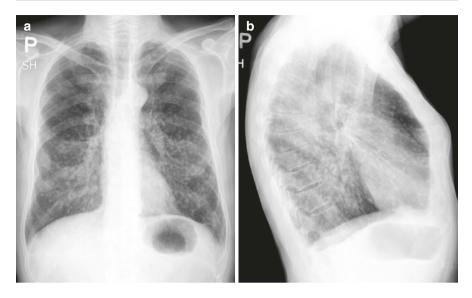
(a) Posteroanterior chest X-ray: pulmonary parenchyma with diffuse multiple small shadows. (b) Lateral chest X-ray: pulmonary parenchyma with diffuse multiple small shadows
